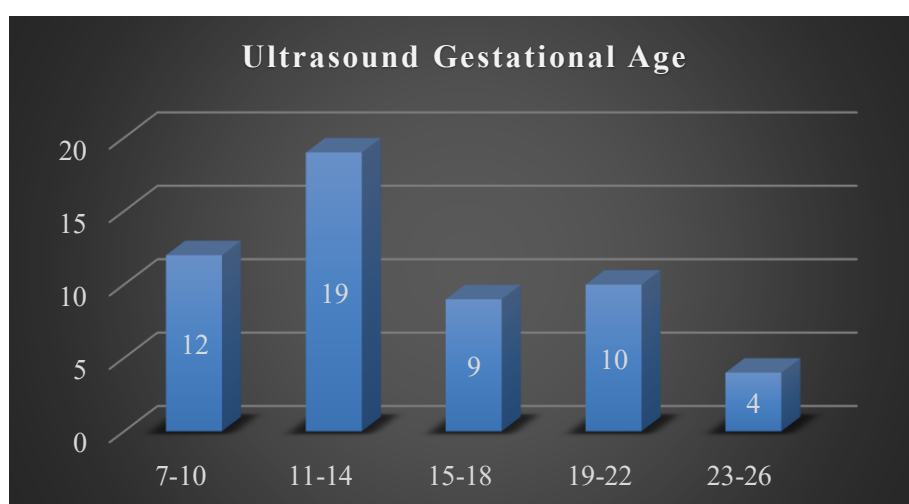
Range of ultrasound gestation in weeks for women with certain menstrual dating where menstrual dating did not concord with ultrasound dating (n=54)
